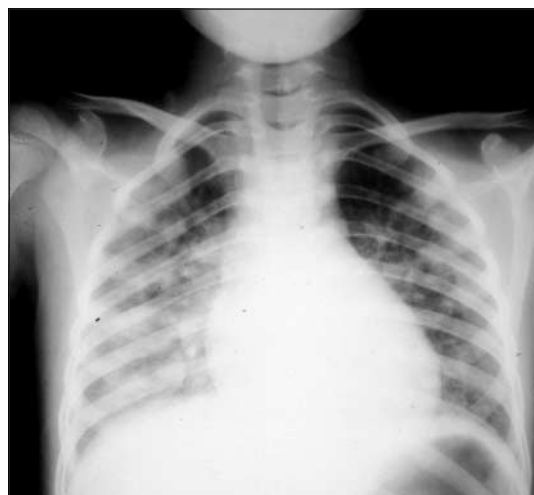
Chest radiograph showing interstitial pulmonary haemorrhage in a child bitten three days earlier (courtesy of R Pugh, Hull)
